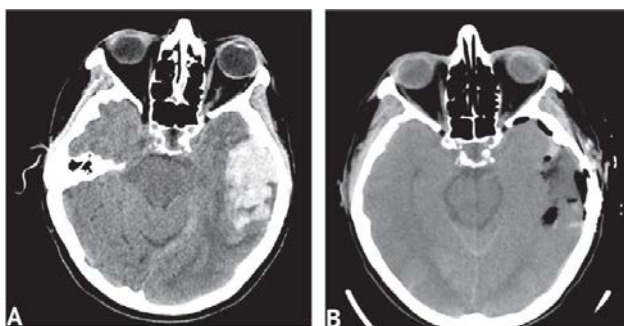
CT scan of the brain, axial projection: A — before surgery; acute subcortical hematoma of the left temporal lobe with a volume of 39 cm³, transverse dislocation to the right up to 10 mm; B — 1 hour after microsurgical removal of the ICH; the hematoma is removed completely, the transverse dislocation to the right up to 3 mm, the gas in the bed of the removed hematoma
